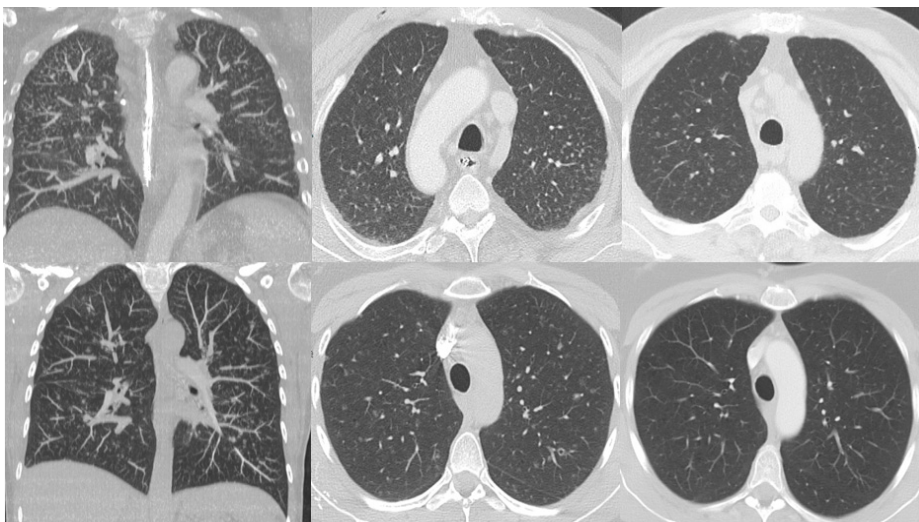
Thoracic CT-morphology of respiratory-bronchiolitis-interstitial lung disease in 2 incidental cases – presence of upper-lobe predominant, diffuse, bipulmonary, miliary, centroacinary, non-solid opacities with (partial) remission after smoking cessation. Axial (left) and coronal (middle) at initial presentation and follow-up after smoking cessation (left) chest CT images in an 58-year old male patient (top row) and in an 52-year-old female patient (bottom row).
